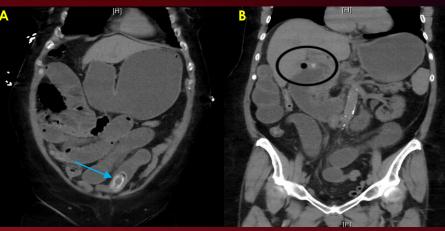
CT demonstrating small bowel obstruction for gallstone. 1B. CT demonstrating cholecystoduodenal fistula.
